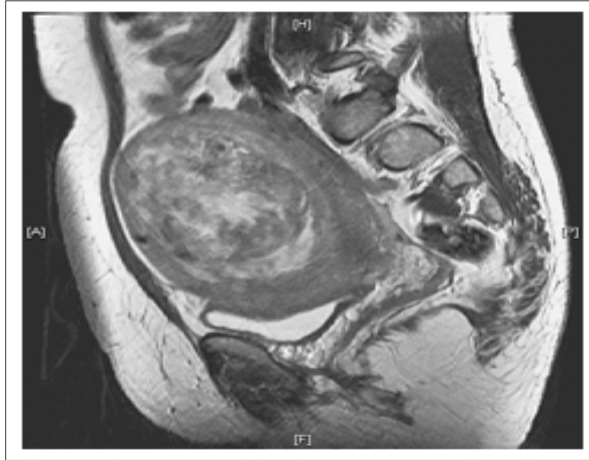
Pretreatment MR image of uterine fibroid (F). Arrows – uterus. P – pubic bone
